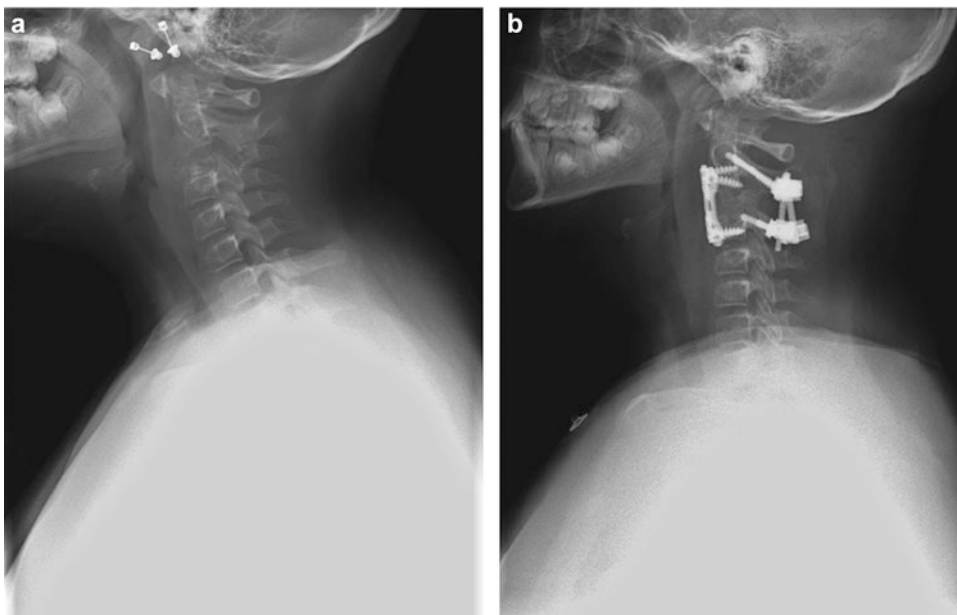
(a, b) Radiographs of a 9-year-old female who successfully underwent a C3 corpectomy with an instrumented C2-C4 anterior arthrodesis, autologous structural iliac crest bone graft, and posterior spinal arthrodesis for her symptomatic eosinophilic granulomatosis involving the anterior, middle, and posterior
